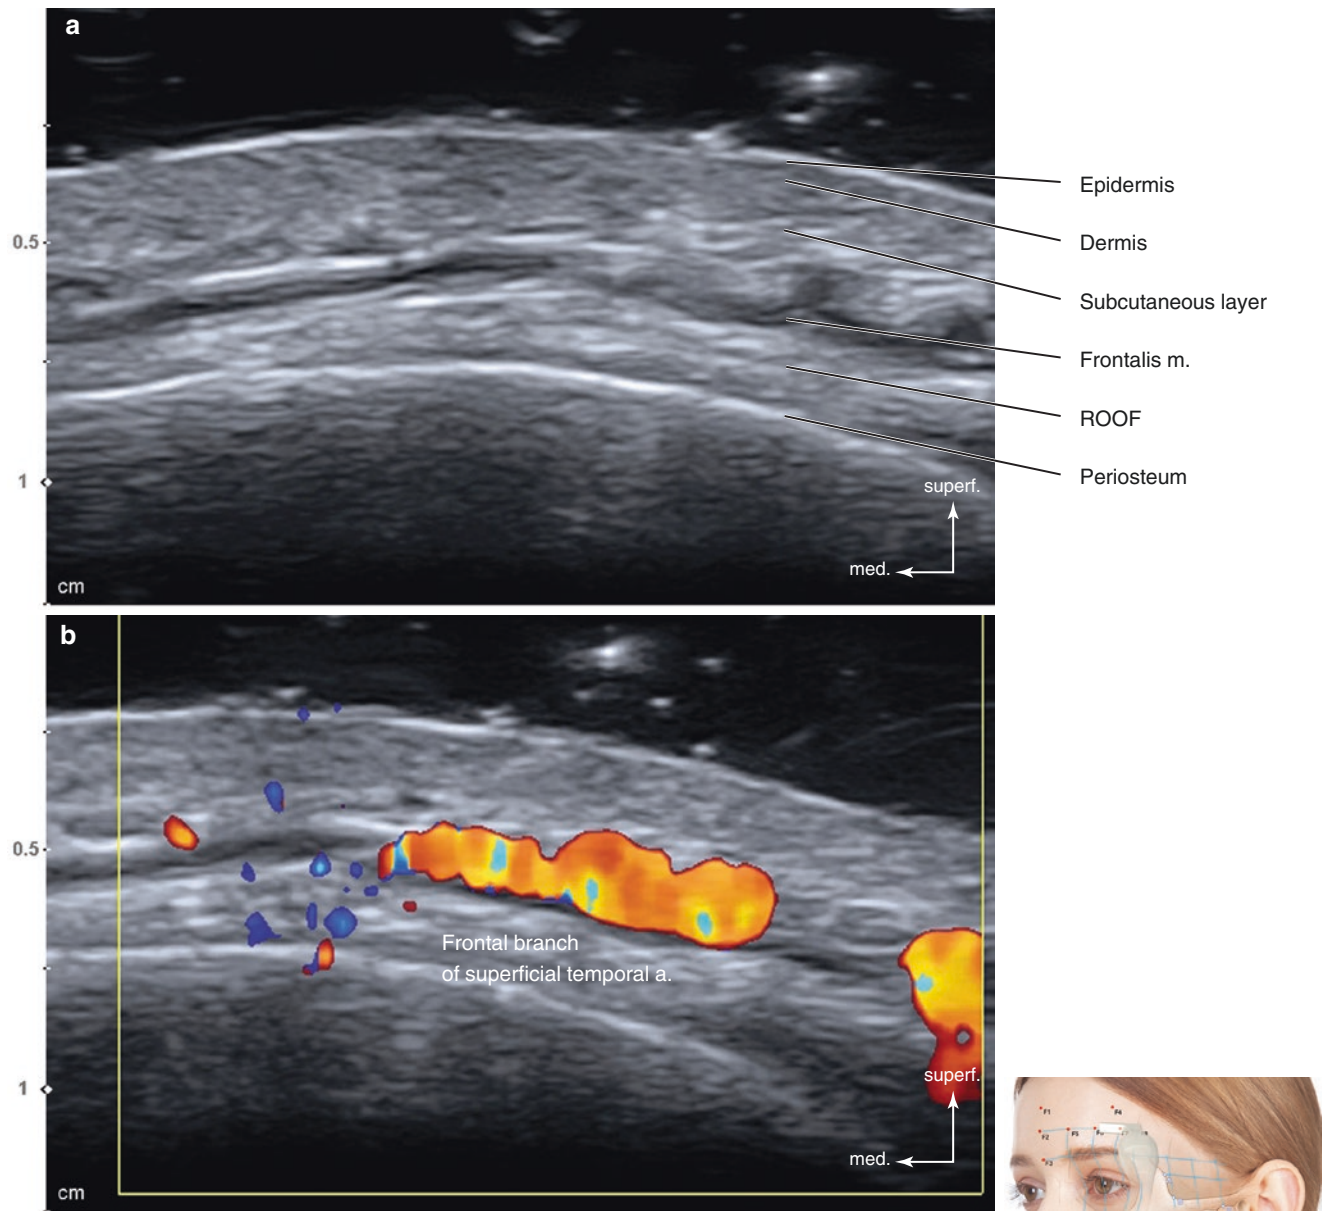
Ultrasonography of the intersection point of TL1 and PL3 (F7). (a) B mode (transverse view, 15 MHz by linear transducer) and (b) Doppler mode (transverse view, 15 MHz by linear transducer). (Published with kind permission of © Hee-Jin Kim 2020. All Rights Reserved)
